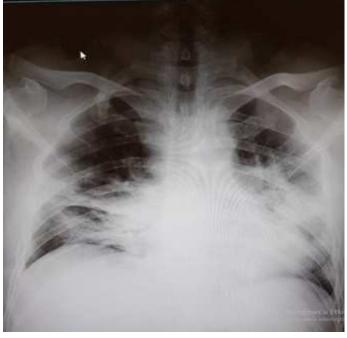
Intensive care hospitalized chest X-ray (Day 5 of hospitalization).
